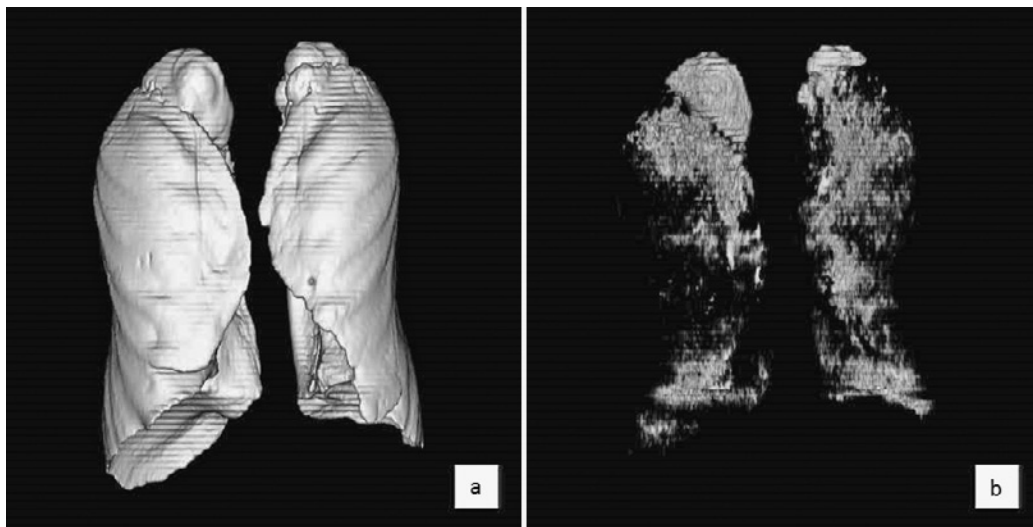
Procedure for 3D-CT volumetry. (a) The volume of a three-dimensional image was calculated as total lung volume (TLV). (b) Volumes < -950 HU were measured as low-attenuation volume (LAV). In this case, the the percentage of LAV (LAV%) was 8.5%.
